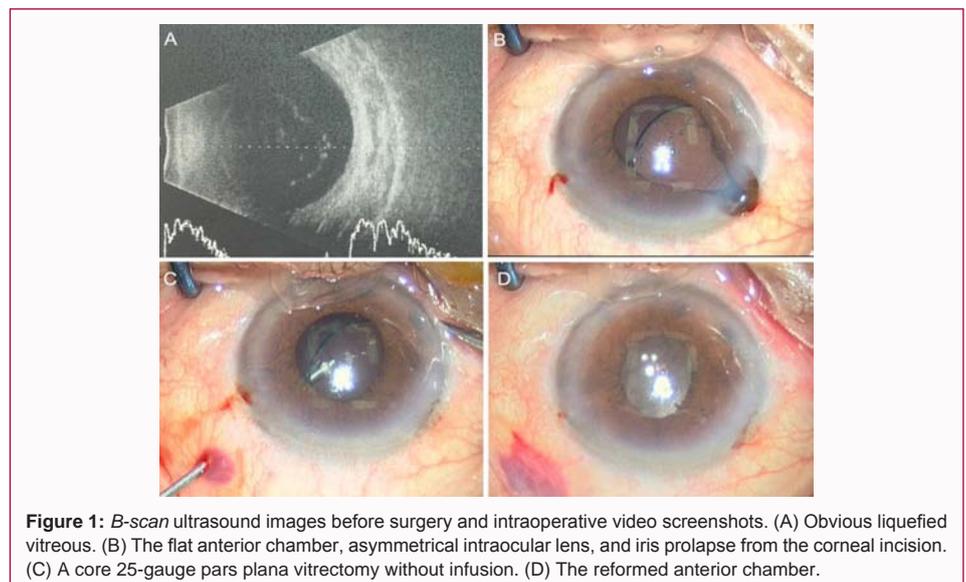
B-scan* ultrasound images before surgery and intraoperative video screenshots. (A) Obvious liquefied vitreous. (B) The flat anterior chamber, asymmetrical intraocular lens, and iris prolapse from the corneal incision. (C) A core 25-gauge pars plana vitrectomy without infusion. (D) The reformed anterior chamber.
